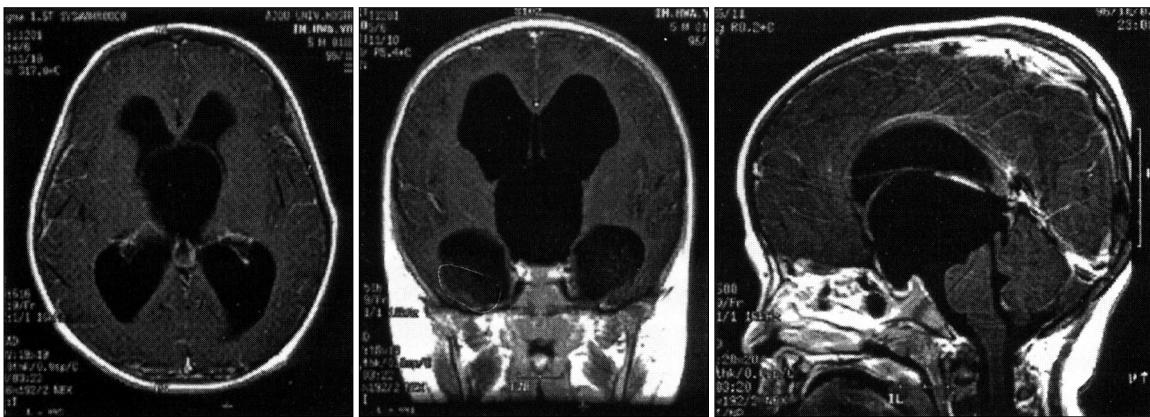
Axial(left), coronal(middle), and sagittal(right) MRI scans show the arachnoid cyst(arrow) in the third ventricle bulging into both enlarged lateral ventricles.
